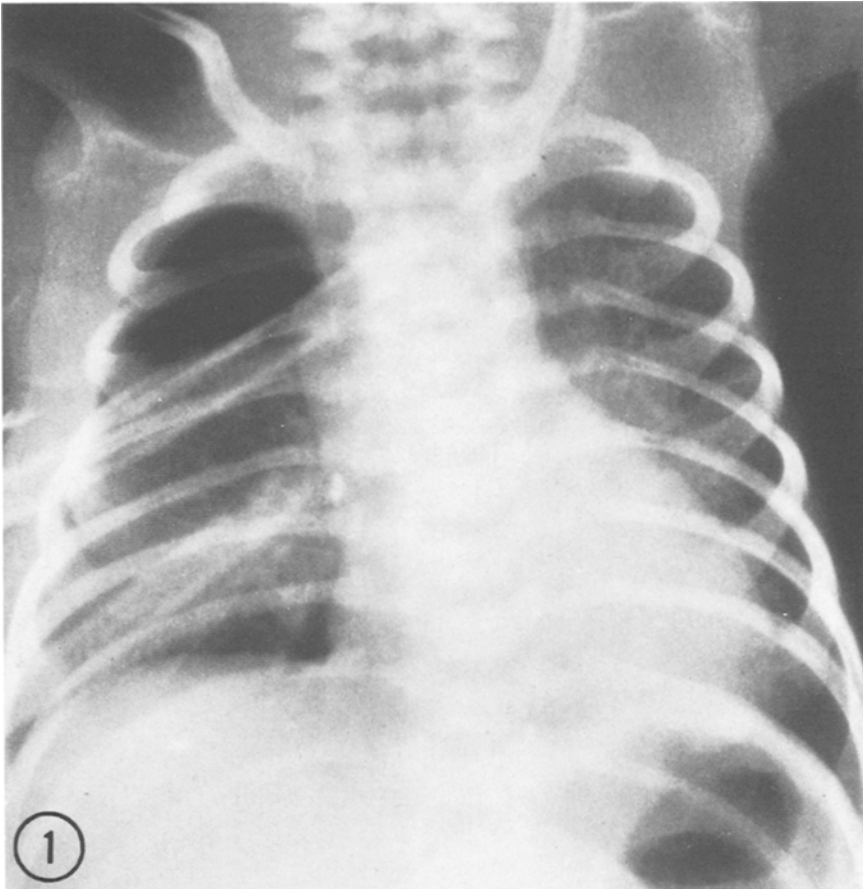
Marked radiolucency was present in the right upper lobe region on chest X-ray
